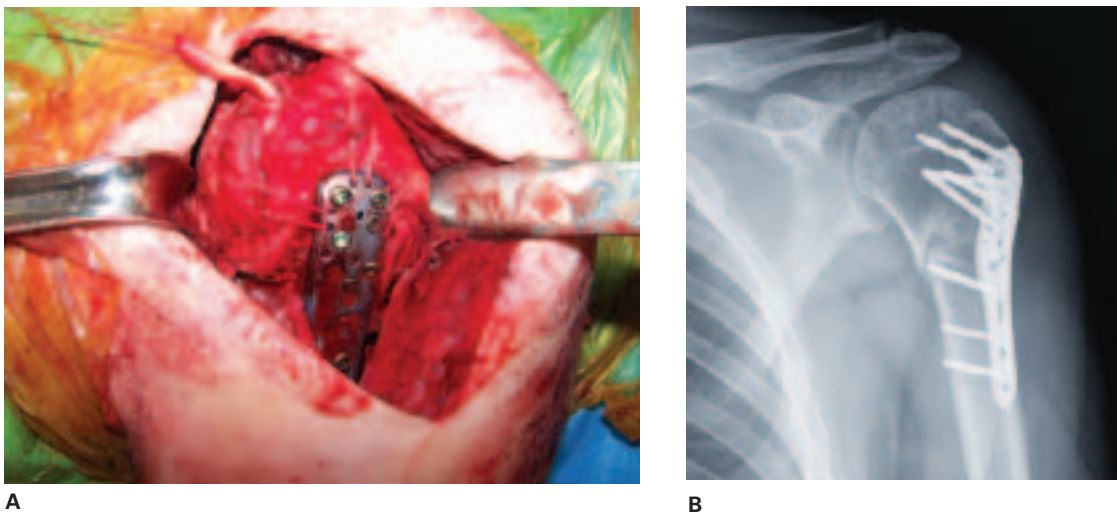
(A) Proximal and distal screws have been inserted and the rotator cuff sutures are secured to the plate affording additional proximal fixation. The long head of the biceps is tenodesed using soft tissue only. The plate is positioned well lateral to the bicipital groove and inferior to the tuberosity to minimize risk of avascular necrosis and plate impingement, respectively. (B) Postreduction radiograph show four to six short (32 – 38mm) locking screws placed to eliminate the risk of intra-articular screw penetration.
